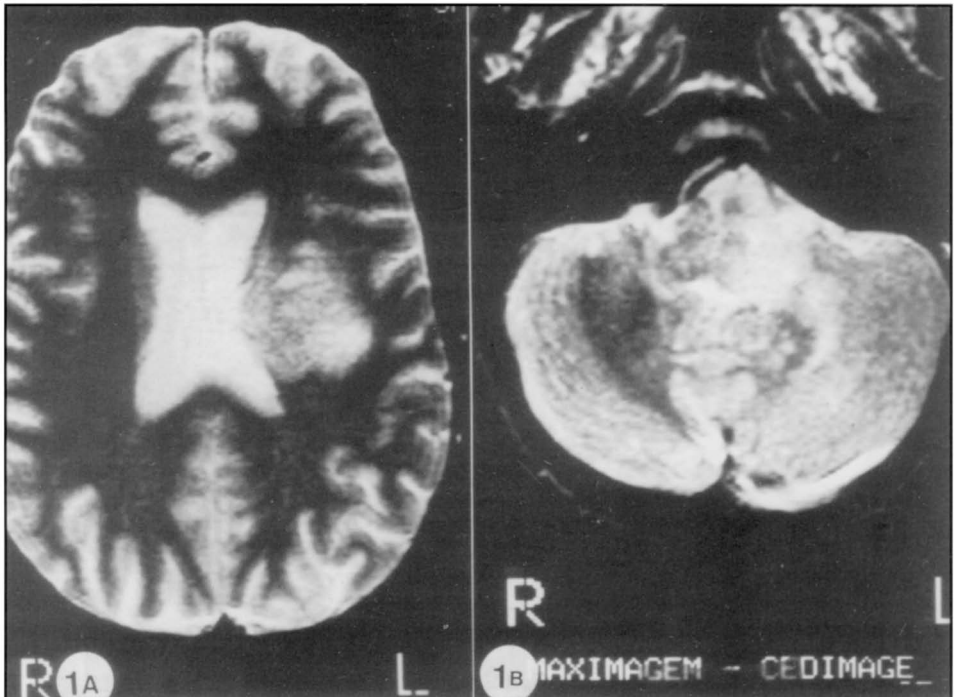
MRI shows hyperintensity in T2 at basal ganglia and at left frontoparietal semi-oval substance(A). Identical aspect in midbrain, bilateral middle cerebellar peduncles and left cerebellar hemisphere (B).
